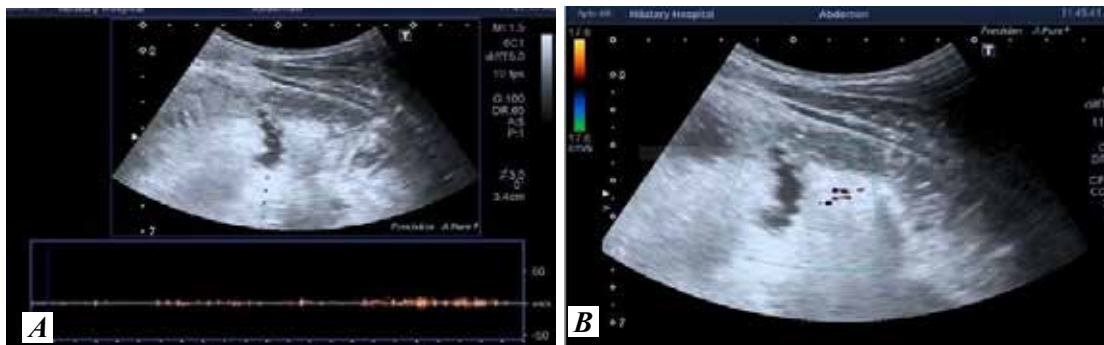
Duplex-Doppler examination of intestinal peristalsis in I group patients
